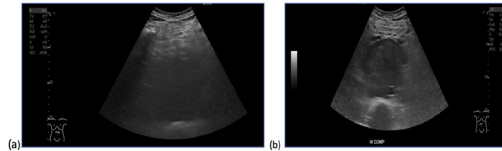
Graded compression on a 44-year-old male who was referred from emergency revealed an intraabdominal solid mass that was later on confirmed on CT scan as a nodal mass, along with multiple hepatic solid masses. This demonstrates how unclear this was in (a), while with compression, the mass was successfully identified after bowel displacement and reducing the distance from the skin surface in (b).
